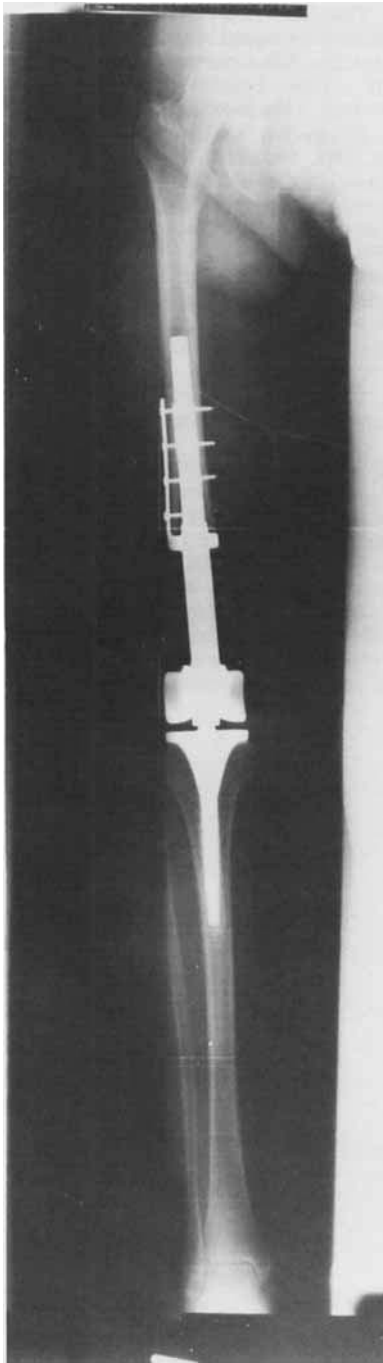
X-ray film of a distal femoral prosthesis.
